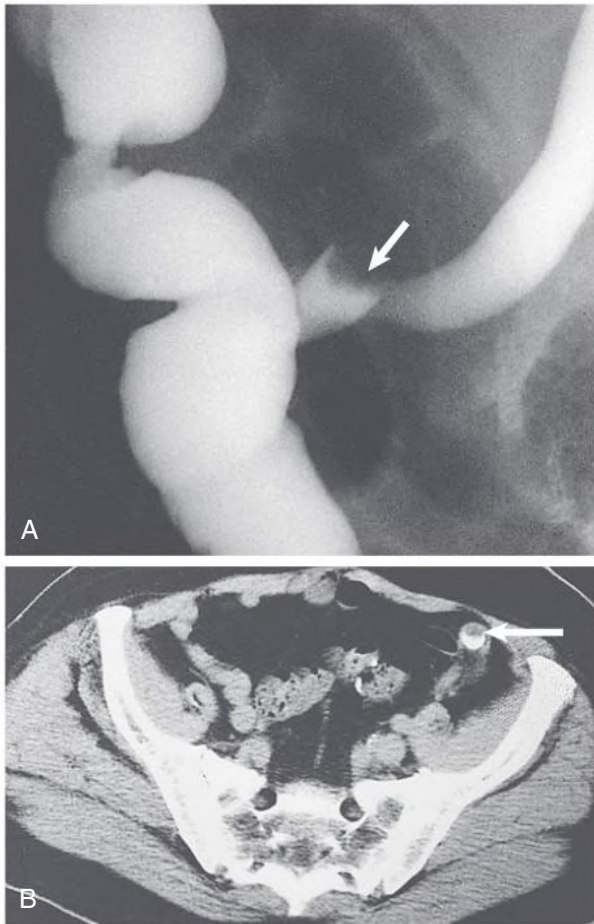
Imaging of an Ileal Conduit. (A) Loop-o-gram. A recurrent transitional carcinoma is present in the reimplanted left ureter (*arrow*). (B) Computed tomography scan clearly shows the tumor as a filling defect in anterior aspect of the opacified ureter (*arrow*).
